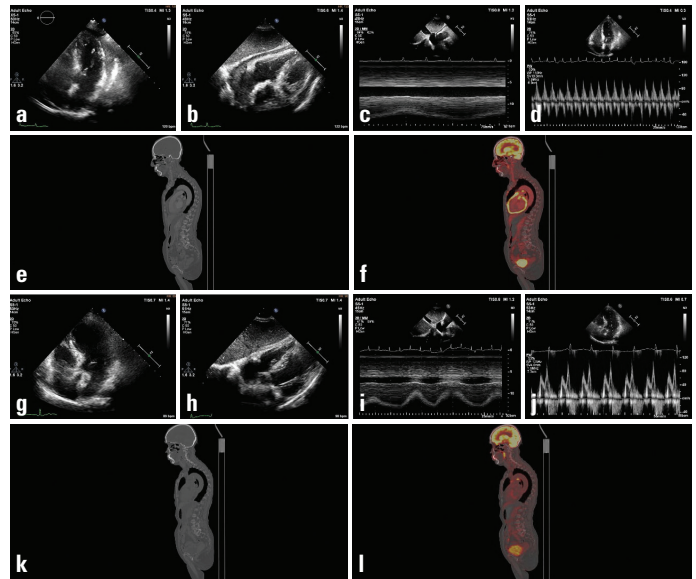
(a) TTE, apical four chamber view, massive hyperechoic pericardial effusion (b) TTE, subcostal view, pericardial effusion (c) TTE, M mode, inferior vena cava plethora (d) TTE, pulse wave Doppler, significant respiratory variation in mitral inflow (e) CT demonstrated 20 mm of pericardial effusion. (f) PET/CT showed increased FDG uptake in the pericardium with an SUVmax of 19.3. (g) TTE, apical four chamber view, resolved pericardial effusion after treatment (h) TTE, subcostal view, resolved pericardial effusion after treatment (i) TTE, M mode, collapse of inferior vena cava with inspiration after treatment (j) TTE, pulse wave Doppler, normalized mitral inflow after treatment (k) CT confirmed resolution of pericardial effusion after treatment. (l) PET/CT confirmed normalized FDG uptake in pericardium after treatment
